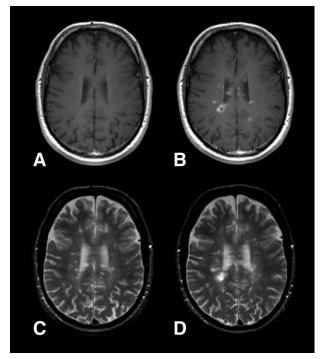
T1-weighted postgadolinium contrast and T2weighted images just before (A, C) and 12 weeks after (B, D) discontinuation of natalizumab in a patient (male, aged 51 years) who discontinued treatment after 21 infusions (completely stable Expanded Disability Status Scale [EDSS] and magnetic resonance imaging [MRI] without new lesions during natalizumab treatment). He had a severe clinical relapse with EDSS worsening of >1 full point. His MRI showed >50 new enhanced lesions (B) and new T2 lesions (D) 12 weeks after discontinuation of natalizumab, whereas no enhancement (A) was observed just before discontinuation.
